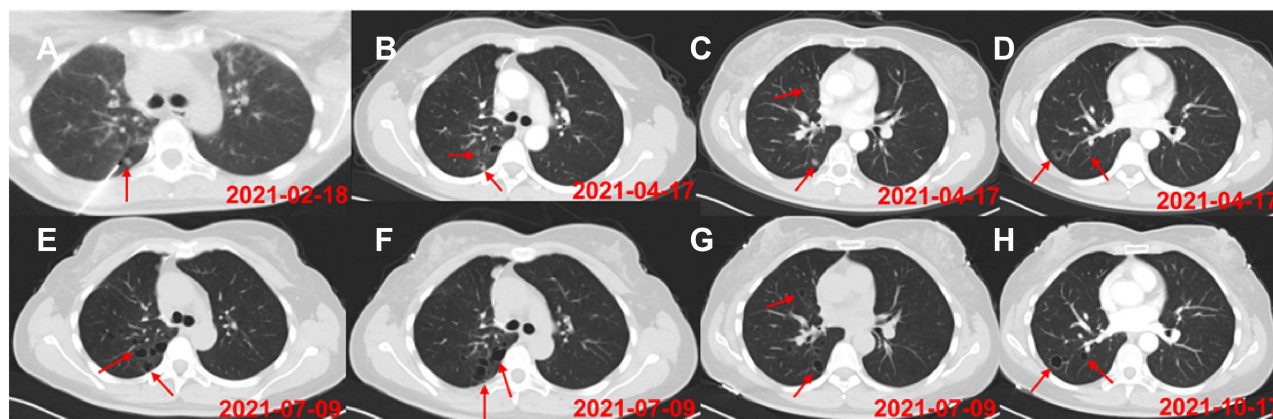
CT shows (A) the puncture position. (B–D) new lung cavities and metastases before treatment with anlotinib. (E–H) stabilization of lung lesions after anlotinib treatment. The red arrows in the figure indicate changes in lesions before and after treatment.
